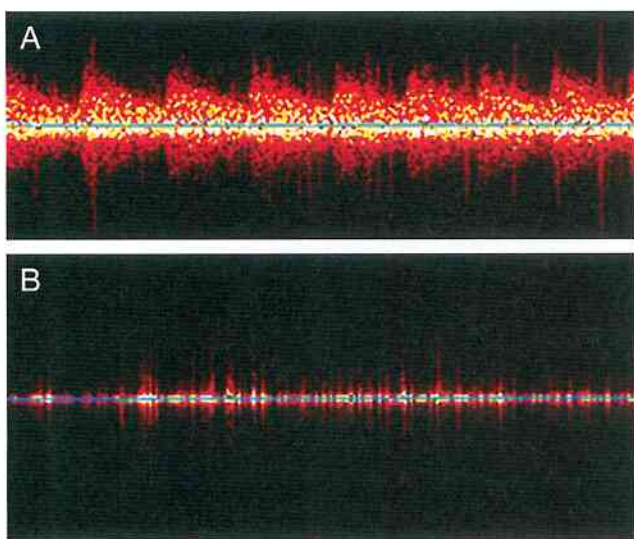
Examples of ultrasound Doppler imaging on a vital tooth (A) and root-filled tooth (B).
